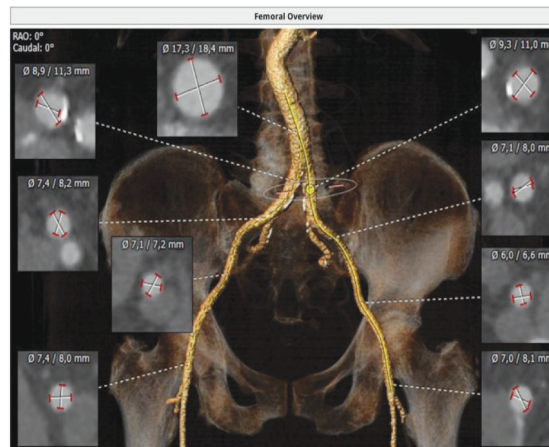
CT, iliac arteries, patient No 1
